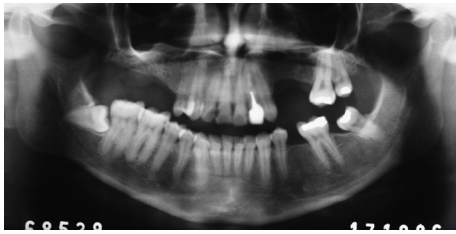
Patient's last yearly panoramic radiograph request in 2006, with no sign of recurrence.
